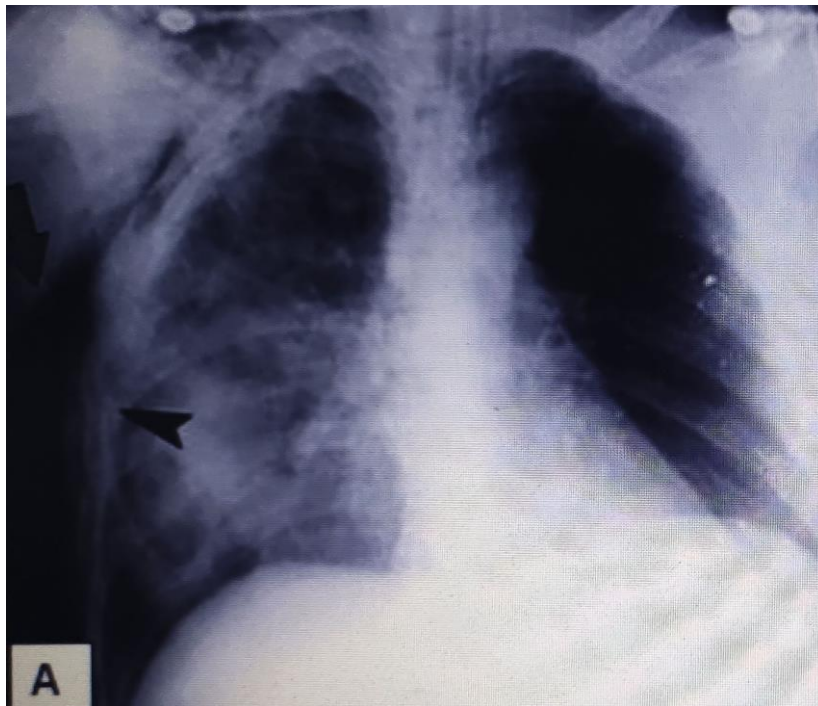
Armor injury. X-ray (A): subcutaneous emphysema, multiple rib fractures on the right, decreased transparency of the right lung. MDCT with contrast (B): contusion of the lower parts of the lungs, mainly on the right, rupture of the lung.
